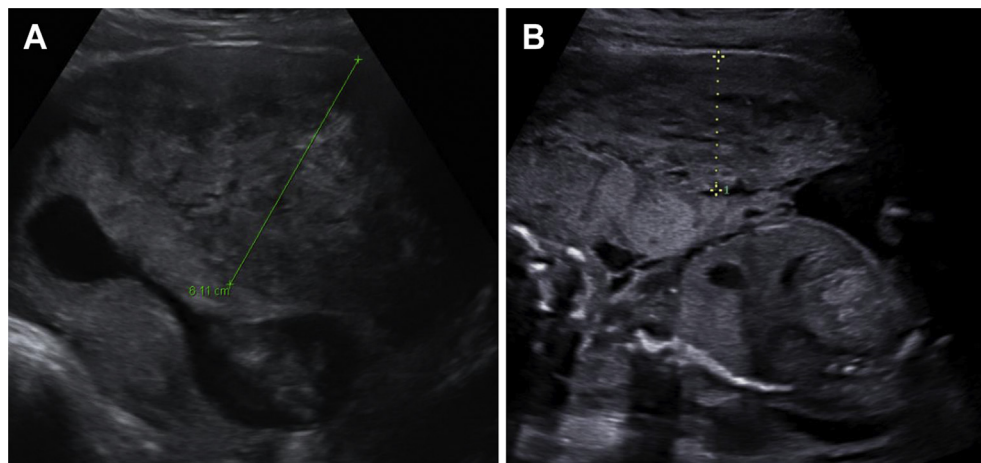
Measurement of uterine wall thickness by transabdominal ultrasonography in the first trimester (A) and the second trimester (B) of pregnancy. The maximal vertical thickness of the anterior or posterior uterine wall affected by adenomyosis was measured.
